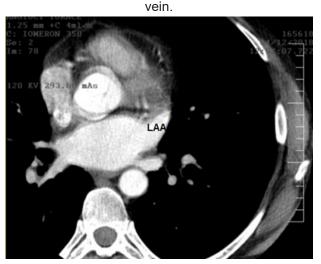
Computed tomography of the heart. The left atrial appendage is an antero-lateral structure, very well represented in his image.
